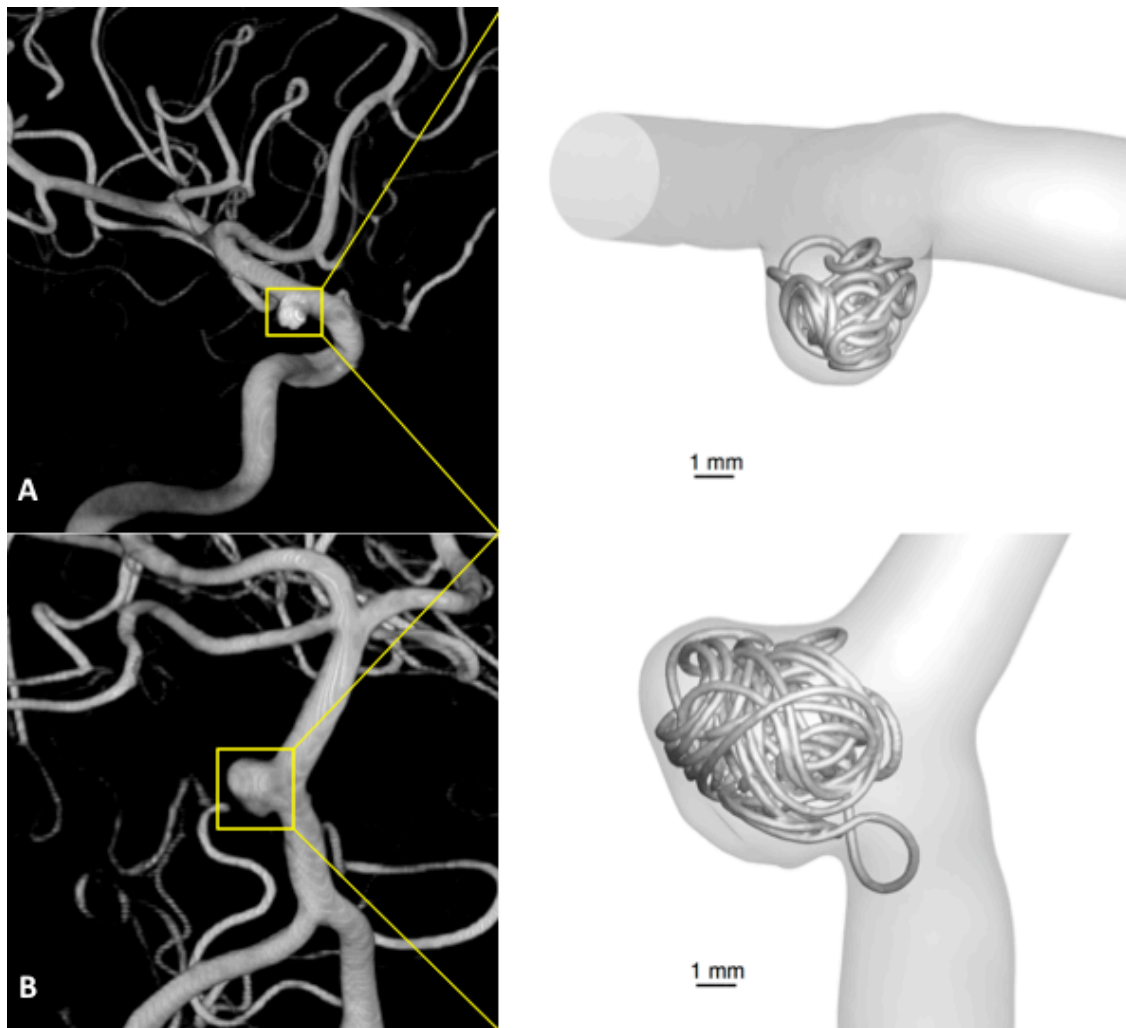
Aneurysm coil surfaces generated from μ CT of treated *in vitro* models for Patients 1 (A) and 2 (B), inserted into three-dimensional rotational angiography of patient-specific vessel and aneurysm anatomy. Individual surface characteristics of each coil, as well as the complex geometry of the coil mass, can be appreciated without beam-hardening artifact.
